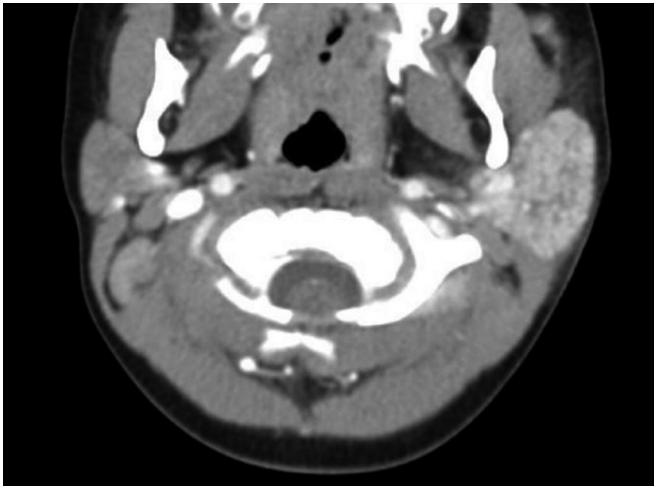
Axial contrast-enhanced CT demonstrates diffuse enhancement and enlargement of the left parotid gland in a child with acute parotitis.
